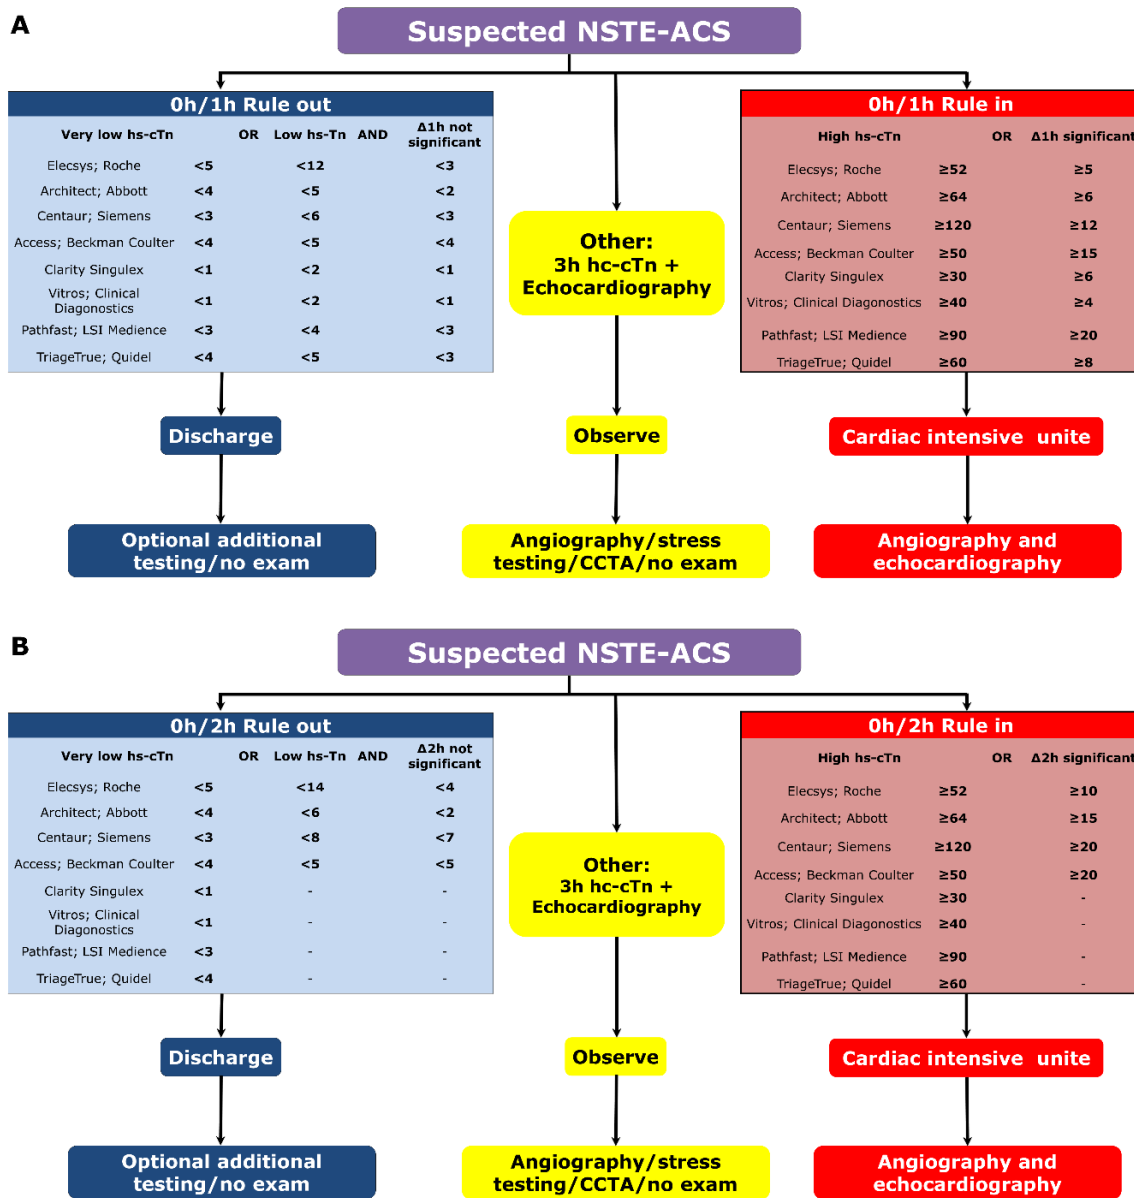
Rule in/Rule out algorithms according to the 2020 ESC NSTEMI guidelines: 0 h/1 h algorithm (A) and 0 h/2 h algorithm (B). STE-ACS: non-ST-segment elevation myocardial infarction; cTn: cardiac troponin; CCTA: coronary computed tomography angiography.
